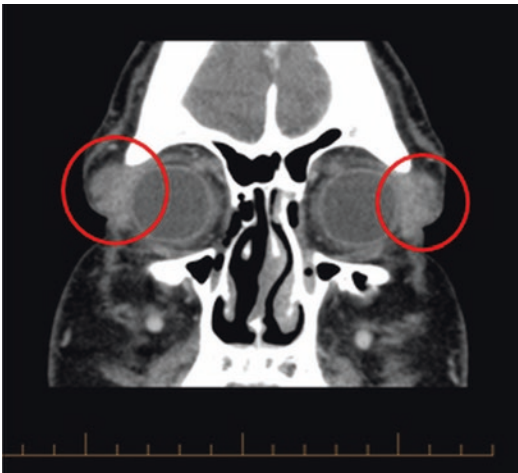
Coronal CT scan demonstrating bilateral lacrimal gland involvement (red circles) in a sarcoidosis patient with dacrocystitis who also has left maxillary sinus disease
